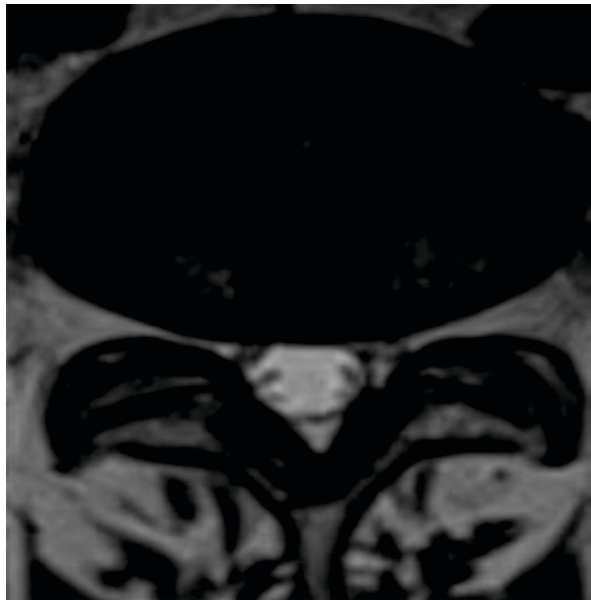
MRI T2 weighted axial image showing diffuse disc bulge of the L4-L5 intervertebral disc causing anterior thecal sac indentation in a 60 years old male patient.
